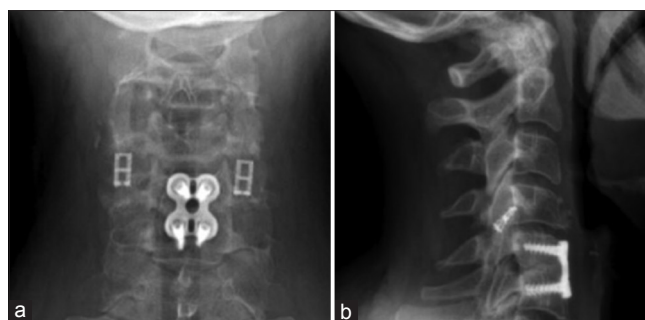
(a and b). Anteroposterior and lateral X-rays of a patient who underwent anterior cervical discectomy and fusion, which resulted in pseudarthrosis. The patient was revised with posterior cervical fusion with bilateral cages
